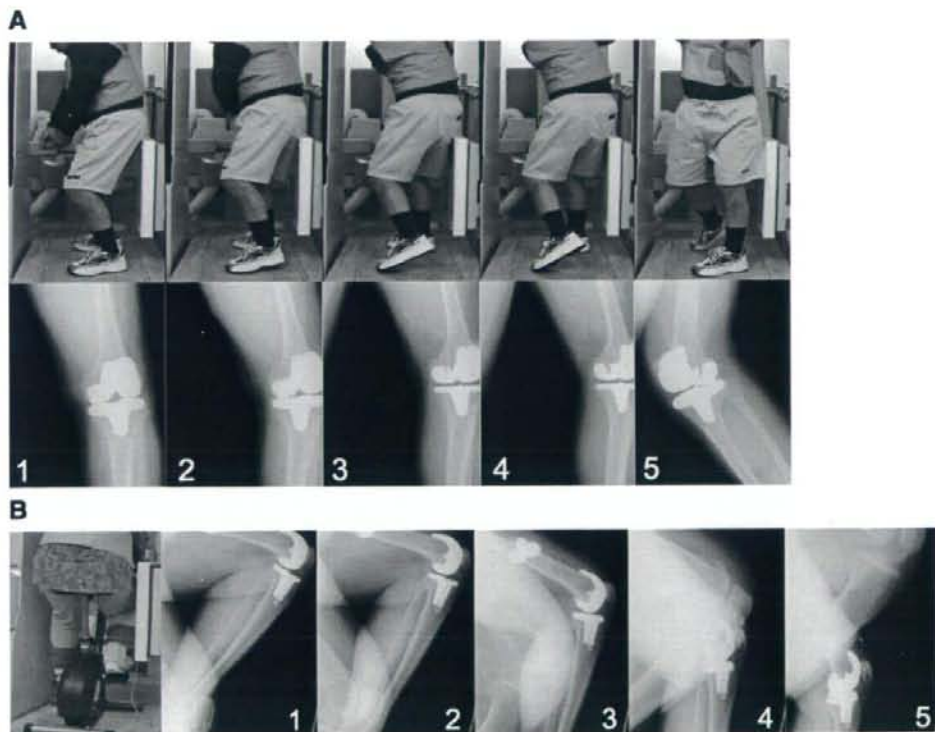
(A) A right-handed subject performed a golf swing (upper stand) while their knee motion was observed using a large flat-panel X-ray image detector. The X-ray images (lower stand) showed the trail (right) knee being studied. Five X-ray images, analyzed using radiographic-based, image-matching techniques were: (1) set-up, (2) early backswing, (3) late backswing, (4) top of the backswing, and (5) end of the follow-through. (B) Each subject performed cycling on a stationary bike at 20 rpm (left) while their knee motion was observed using a large flat-panel X-ray image detector. Continuous X-ray images, taken at 3 frames per second, show the right knee from the top position of the crank to the bottom position being studied: (1) top position, (2) 25% phase, (3) 50% phase, (4) 75% phase, and (5) bottom position.
